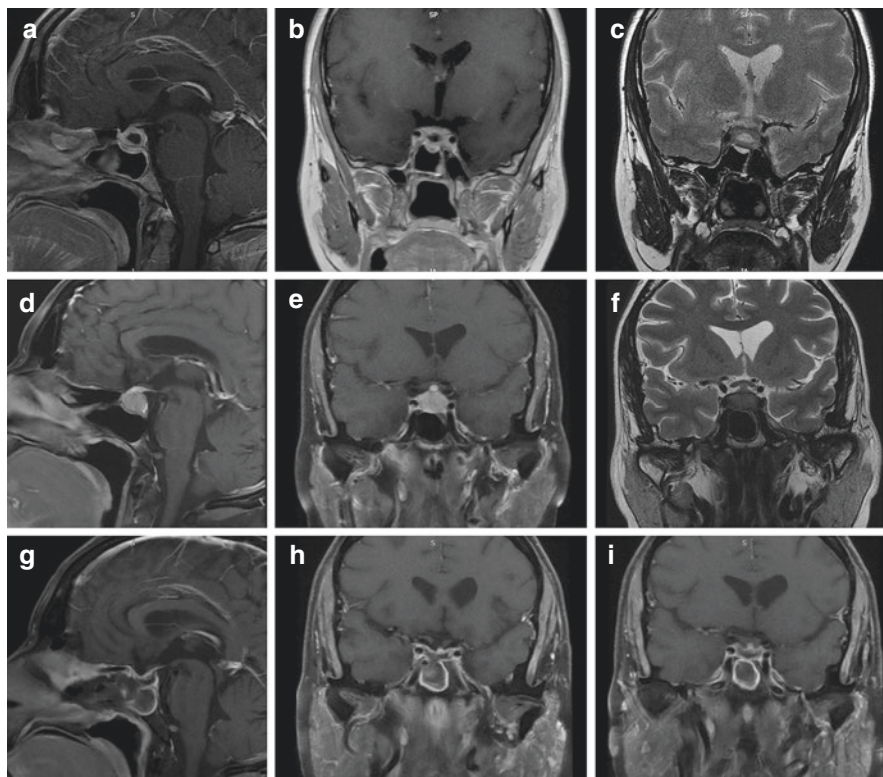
Pituitary xanthogranuloma. First set of MR images (a–c) with a picture suggestive of hypophysitis. Repeat imaging (d–f) after medical treatment. (g–i) Postoperative MR images after endoscopic endonasal transsphenoidal approach
